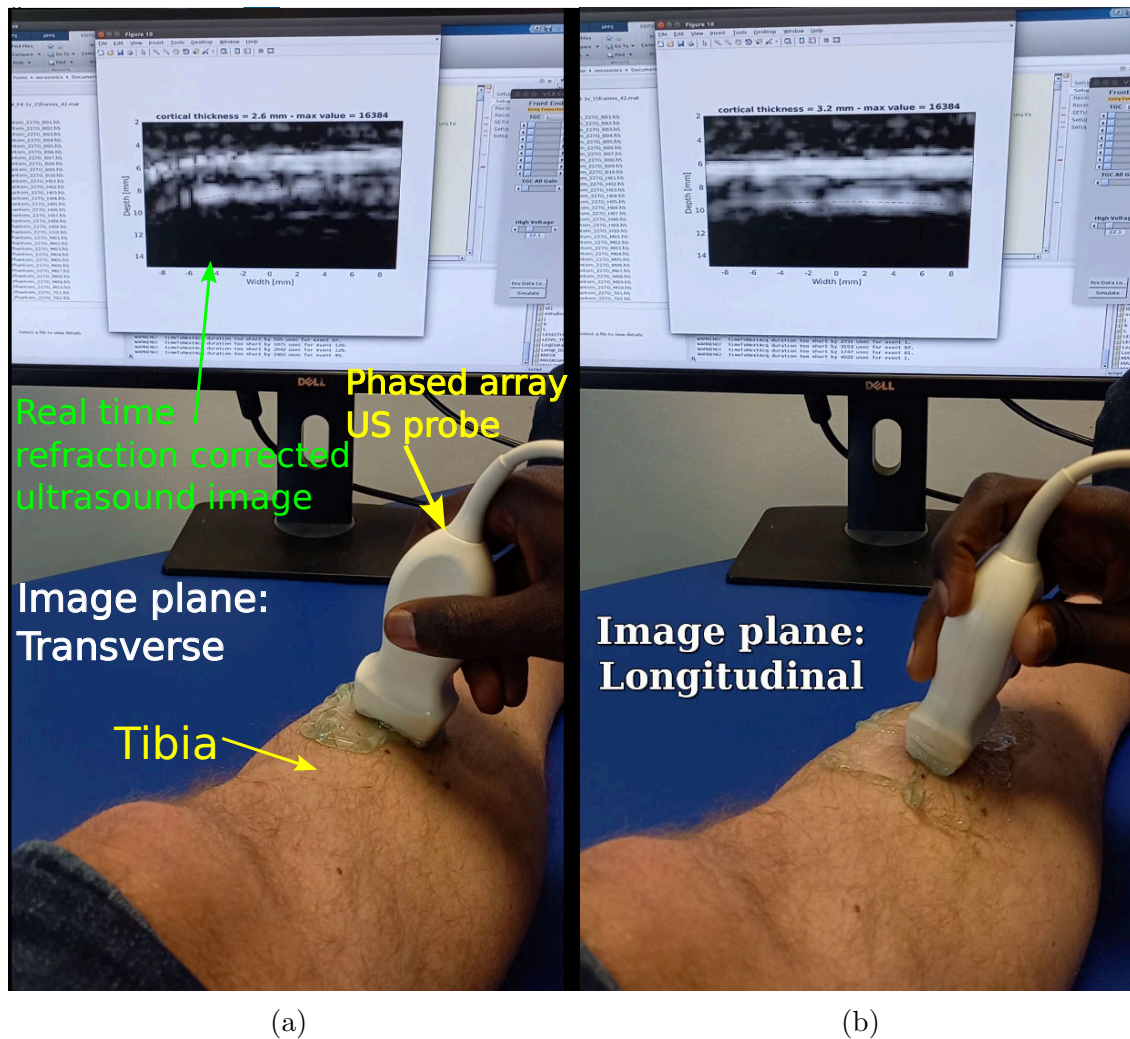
Configuration for acquisition of ultrasound data. Panel (a): probe is placed perpendicular to bone axis (transverse). Panel (b): probe is placed along bone axis (longitudinal).
